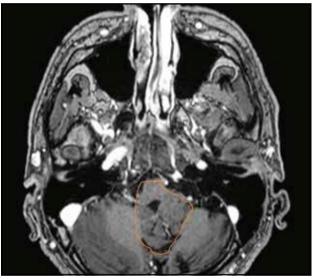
Contrast-enhanced cranio-cerebral MRI (T2 and T1 signalaxial section) reveals a nodular mass in the left side of the Luschka foramen extended to the fourth ventricle and left cerebellar peduncle.
